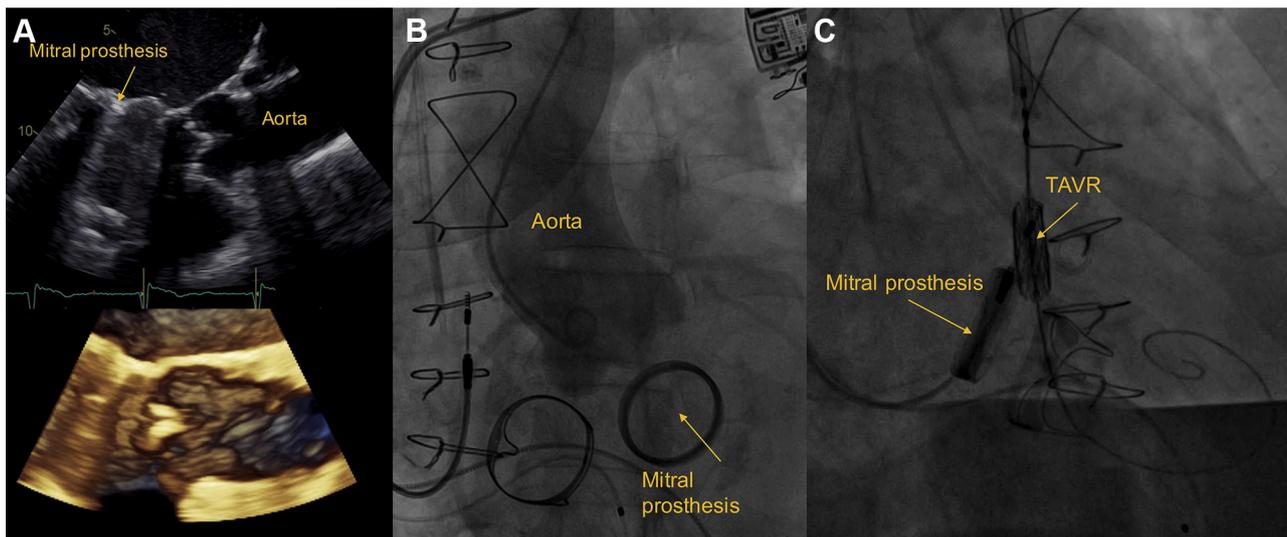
Multimodality imaging to assess mitroaortic spatial relationship. At transesophageal 2D (upper A) and 3D (lower A) echocardiography midesophageal 120° scan visualizes the MV prosthesis and the left ventricular outflow tract (LVOT). At fluoroscopy, a left anterior oblique projection shows an *en-face* view of the MV prosthesis (B); (C) right anterior oblique projection.
